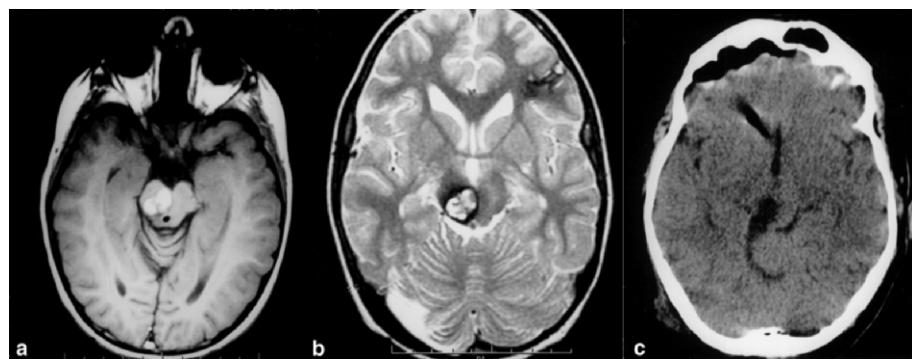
Case 2: a 7-year-old boy. Preoperative axial T<sub>1</sub>-weighted image (a) and T<sub>2</sub>-weighted image (b), revealing hematomas with low intensity rim in the right tegmentum and left frontal lobe. Postoperative CT (c) showing the surgical corridor.
